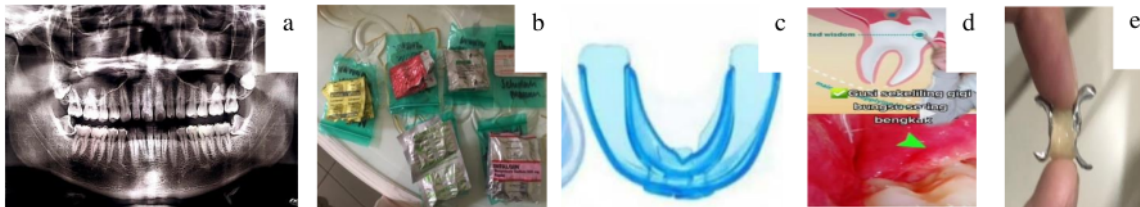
Other images during teleconsultation, besides clinical intra oral or extra oral photos. a. radiograph, b. medicine, c. e-commerce, d. dental education material, e. miscellaneous
